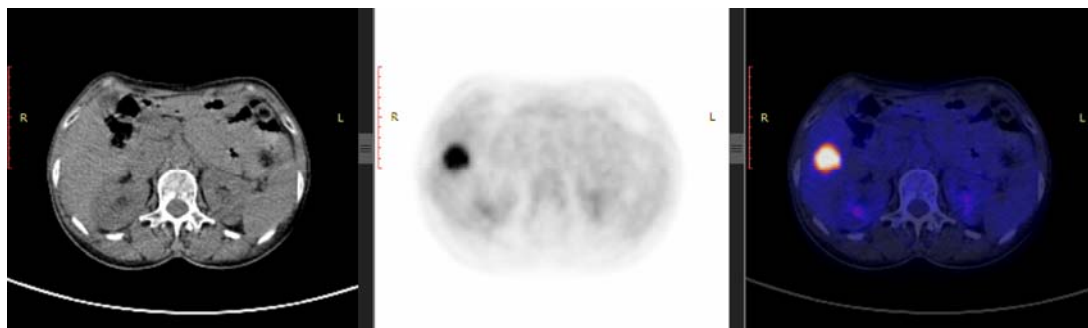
A 57-year-old woman with invasive ductal carcinoma of the left breast. The patient underwent mastectomy followed by adjuvant chemotherapy, paclitaxel (Taxol[®]) and trastuzumab (Herceptin[®]). Transaxial images show a hypermetabolic liver mass in S6 segment, 3.1cm in size, SUVmax = 12.5 corresponding to hepatic involvement. SUV – standardized uptake value.
